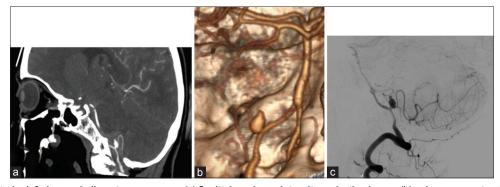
Right posterior inferior cerebellar artery aneurysm. (a) Sagittal maximum intensity projection image, (b) volume-reconstructed image, (c) digital subtraction angiography image in lateral view of the same patient showing a saccular aneurysm in the proximal part of posterior inferior cerebellar artery just after its origin. A nipple-like projection can be seen from its superior aspect in both computed tomography angiography and digital subtraction angiography images
